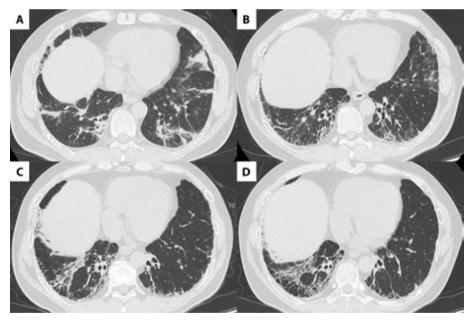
Representative HRCT images of ARS-ILD showing the UIP pattern. (A) High-resolution computed tomography (HRCT) images of a 56-year-old man positive for anti-Jo-1 antibody show the usual interstitial pneumonia (UIP) pattern. (B) HRCT images of a 69-year-old man positive for anti-EJ antibody and anti-PL-7 antibody show the UIP pattern. (C) HRCT images of a 64-year-old man positive for anti-EJ antibody show the UIP pattern. (D) HRCT images of a 66-year-old woman positive for other anti-ARS antibody show the UIP pattern.
